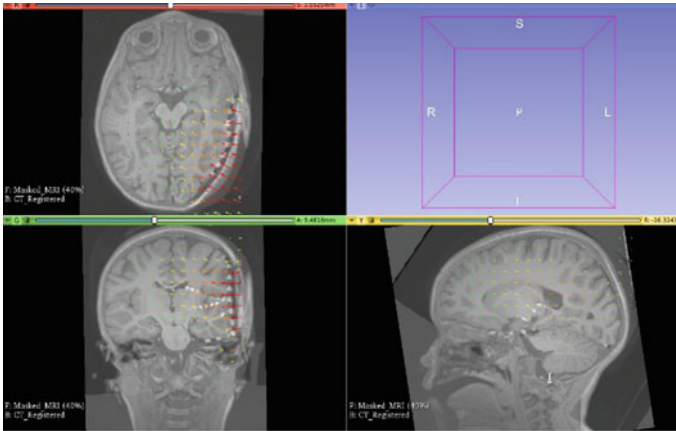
Visualization of the transformed preoperative MRI using deformation field computed by MTLED registered onto a CT with implanted intracranial electrodes. Visualization performed with 3D Slicer www.slicer.org [5]
